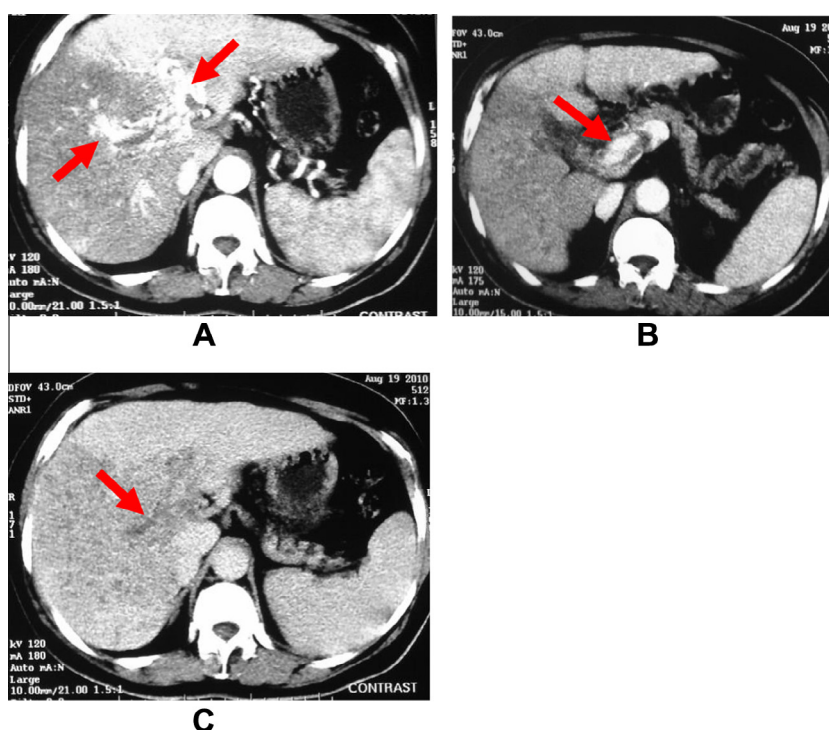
Central APS with portal venous thrombosis: 57 year old male patient with liver cirrhosis and diffuse neoplastic infiltration of the right lobe. (A) Axial CT at the arterial phase shows intense enhancement of the right and left portal veins (red arrows) with differential enhancement of the right and left lobes (B) Non-obstructing mural thrombus is present at the main portal vein (arrow) (C) The right portal vein shows tumoral thrombosis (arrow). The hypodensity of the right lobe reflects an element of infarction. No interventional procedure was done and further management was carried out by medical liver support.
